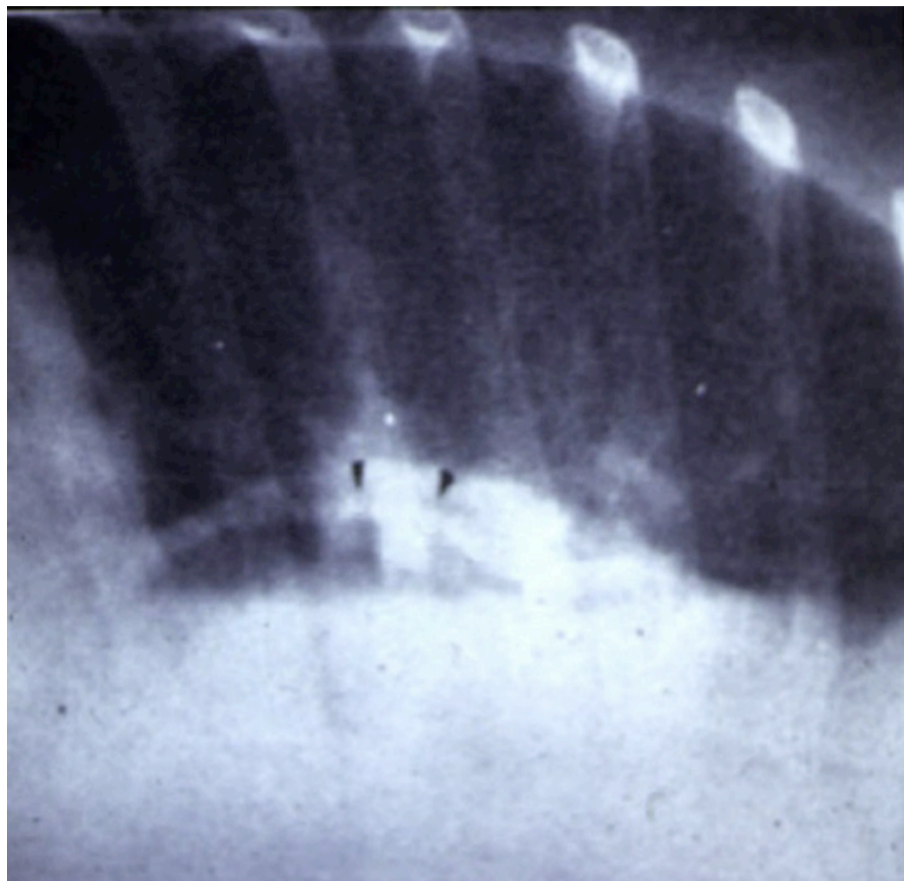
Left lateral decubitus chest x-ray after the administration of intravenous CO₂ for pericardial evaluation. The CO₂ bubble trapped in the nondependent portion of the right atrium is seen as a negative contrast.
